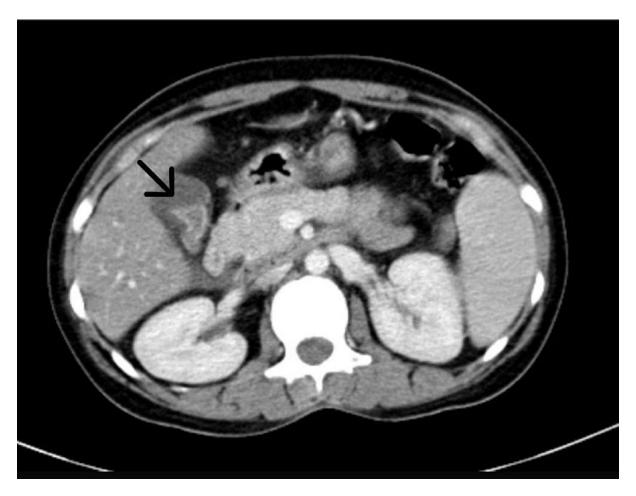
Contrast-Enhanced Computed Tomography of the Abdomen showing decreased parenchymal density of liver with homogenous post-contrast enhancement
